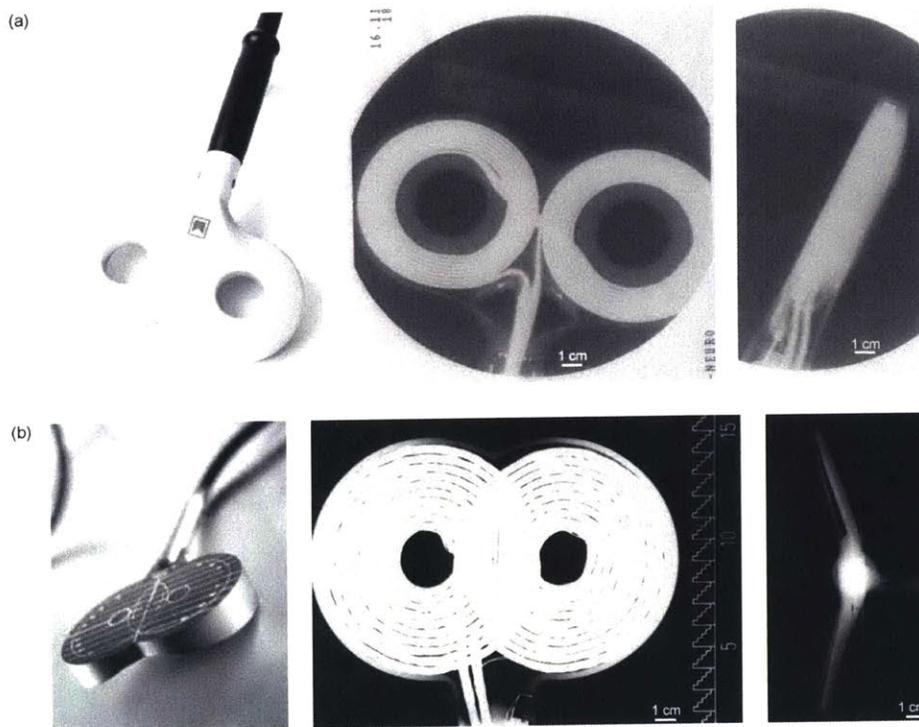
X-ray of commercial Magstim and Medtronic figure-of-8 coils (Thielscher and Kammer 2004).
